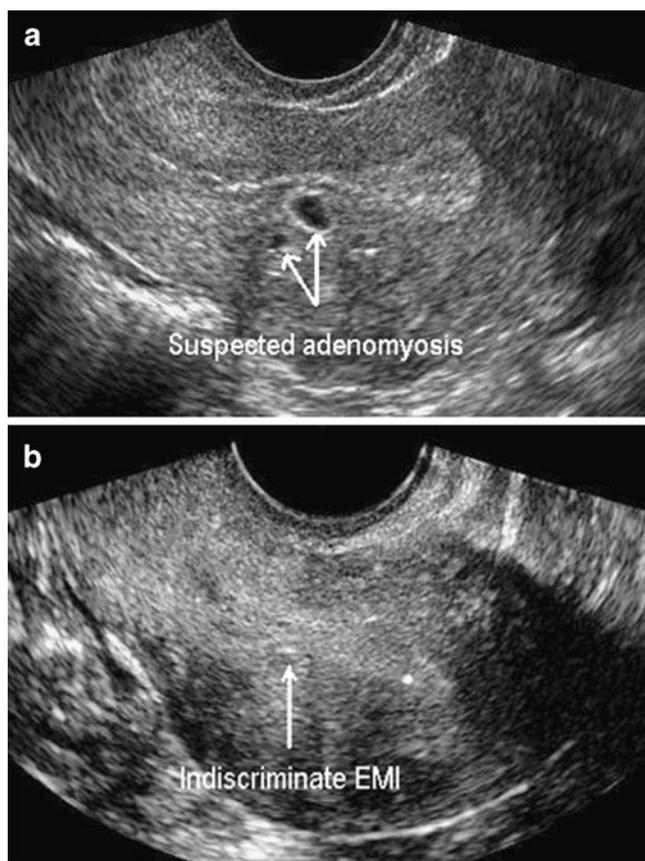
a Image is an anterior/posterior view of a uterus showing subendometrial cysts with echogenic margin in the posterior uterine wall during the luteal phase of the cycle. b Image is a similar ultrasound view to the one shown in a. It shows early follicular phase indiscriminate EMI and disappearance of the cystic subendometrial lesions depicted in a
